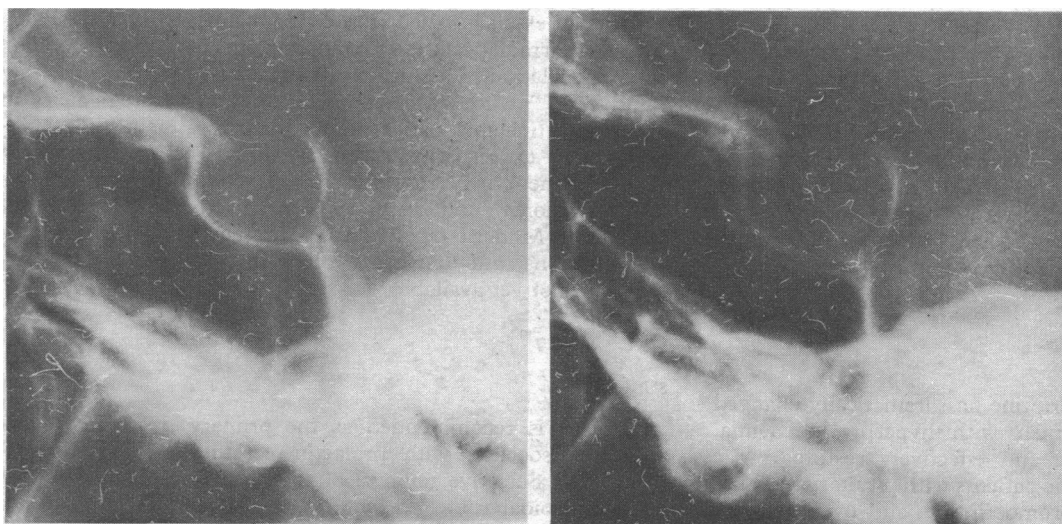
Case 3. X-ray pictures of pituitary fossa before (left) and after bromocriptine-induced pregnancy (right) in 25-year-old hyperprolactinaemic woman with primary amenorrhoea who developed severe headache during second trimester. Before pregnancy sella is slightly asymmetric; after pregnancy sella is changed in shape and enlarged.
